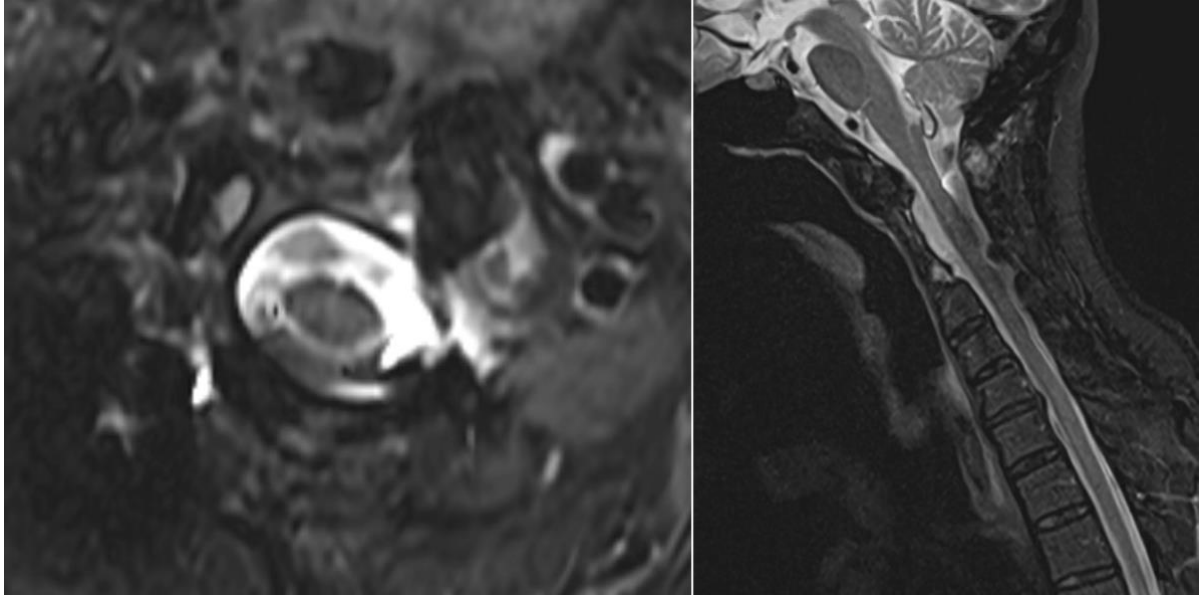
Postoperative MRI demonstrating resection of the tumour with no evidence of recurrence
